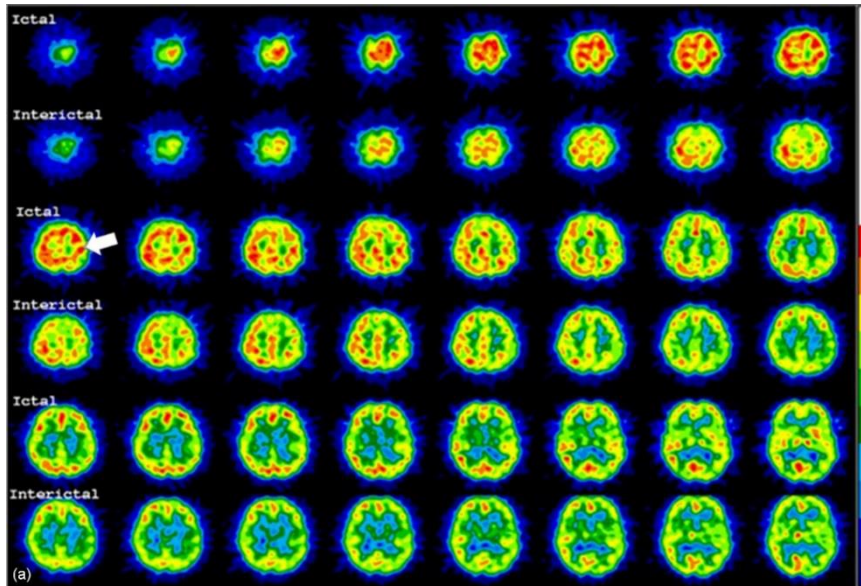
Image color adjustment for ictal and interictal SPECT for visual interpretation. Step 1 (a): Color in ictal phase is adjusted to see a single point of maximum color (in the left parietal cortex in this patient). This is the area of maximum perfusion change. Step 2 (b): Then, adjust the color in interictal phase by matching color in the areas of presumed uninvolved region (the right temporal lobe in this patient) (arrows)
